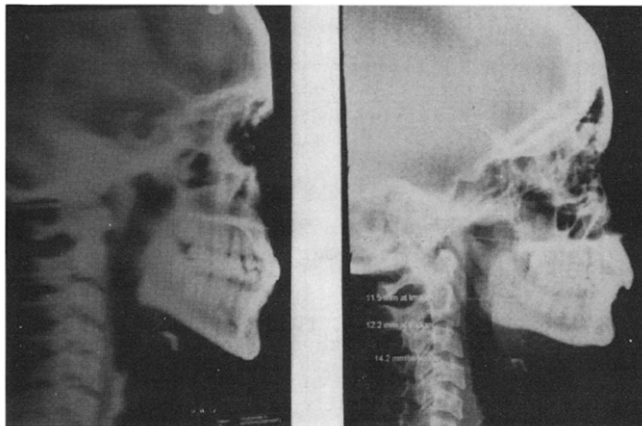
2- Cephalometric radiographs on male (on right side) and female (on left side) subjects.
